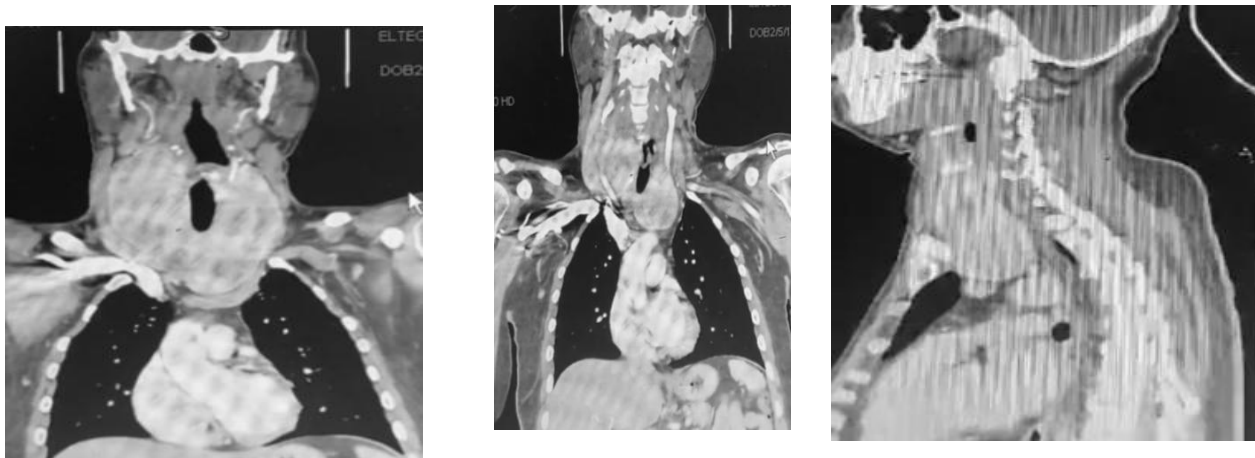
CT scan of the neck and chest shows huge right thyroid lobe and left intrathoracic lobe over the arch of the aorta.
